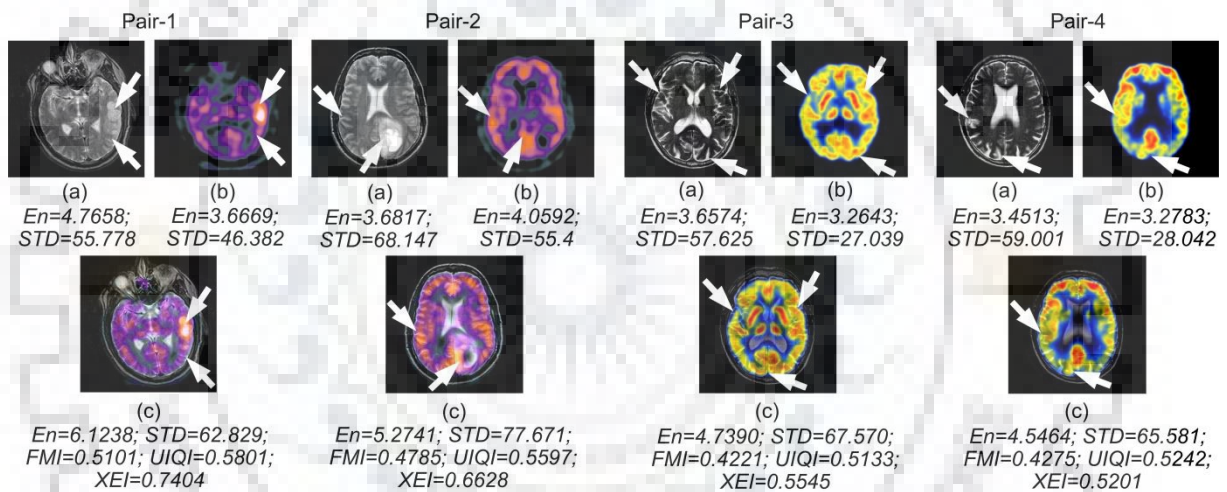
Fused images using the proposed SDL-MIF method on various test neurological images along with quantitative values. Pair 1 and 2 input (a) MR image (b) SPECT image (c) Fused image, Pair-3 and 4 input image (a) MR image (b) PET image (c) Fused image
